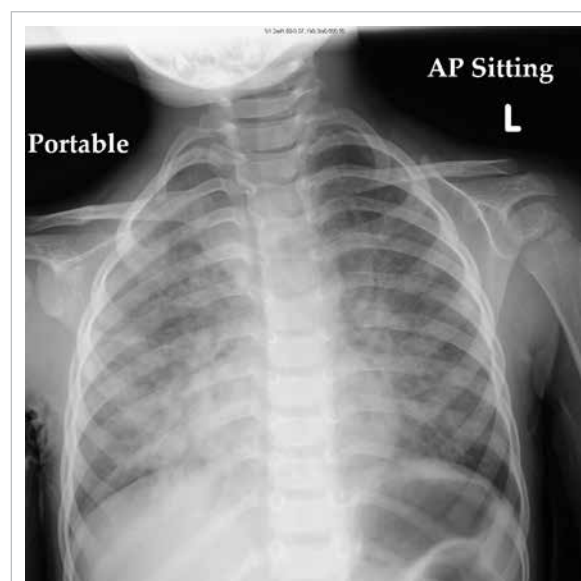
Chest X-ray—bilateral patchy and confluent airspace opacities in both lungs of the patient, which were more pronounced over the middle and lower zones with consolidation over the right middle and lower zones
